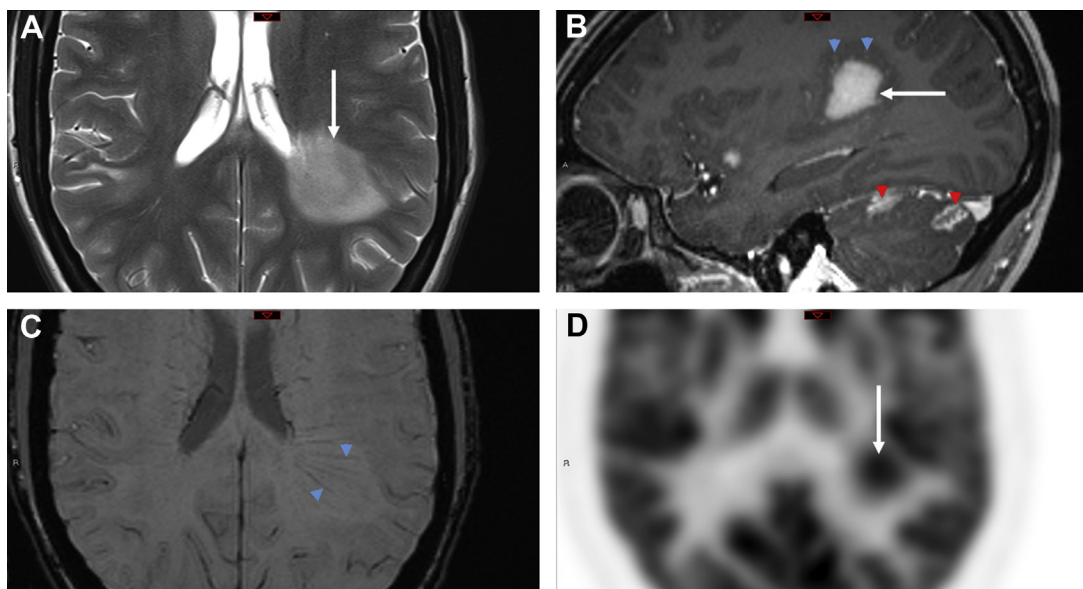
Neurosarcoidosis. Axial T2-weighted MR image (A), sagittal T1-weighted postcontrast MR image (B), axial SWI MR image (C), and axial fluorodeoxyglucose PET image (D) in a 23 year old presenting with multiple subacute focal neurologic deficits. A mass-like area of left peritrial signal abnormality demonstrates slightly mixed intermediate/high T2 signal (white arrow in A) with corresponding homogeneous enhancement (white arrow in B). Note that the medullary veins maintain a straight course through the lesion and demonstrate slight engorgement on SWI and postcontrast series (blue arrowheads in B and C). Additional areas of cerebellar folia parenchymal and leptomeningeal enhancement are present (red arrowheads in B). Fluorodeoxyglucose PET images show radio-tracer accumulation within the peritrial lesion (white arrow in D), measuring an average and maximum standardized uptake value of 9.2 and 12.9, respectively.
